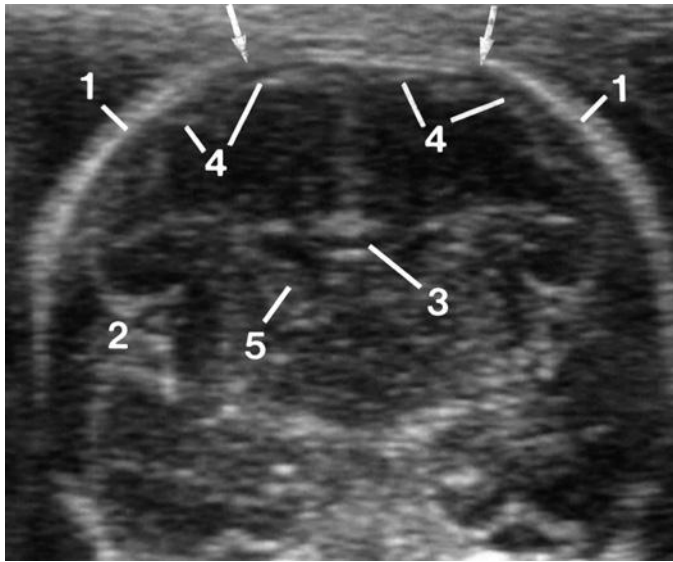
The sonographic beam was directed through the anterior fontanelle (arrows) in a midtrimester fetus, enabling recognition of striking detail in the fetal brain because of the "bone-free window." 1, parietal bone; 2, lateral fissure; 3, corpus callosum; 4, brain edges over the most cephalic portions of the parietal lobes; 5, head of caudate nucleus.
